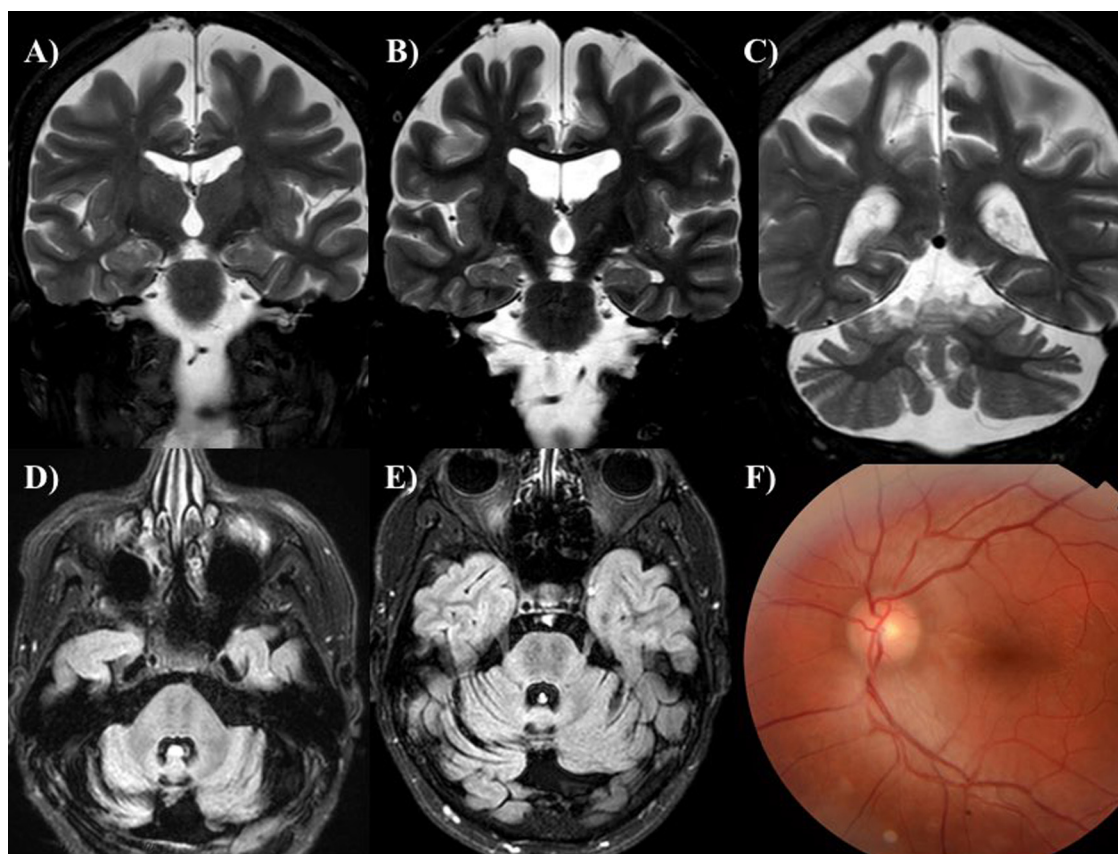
Characteristic MRI and ophthalmological findings. Bilateral frontal and parietal atrophy is presented on coronal T2 images for Patient 1 at age 47 years (A) and for Patient 4 at age 30 years (B). Coronal T2 image for Patient 1 demonstrates predominant superior vermis atrophy (C). Axial TIRM cross-sections show linear hypointensities in the pons for Patients 1 (D) and 4 (E). Retinal fundus examination reveals increased demarcation of the nerve fibers close to the optic disk, due to a retinal nerve fiber hypertrophy (Patient 4, F).
